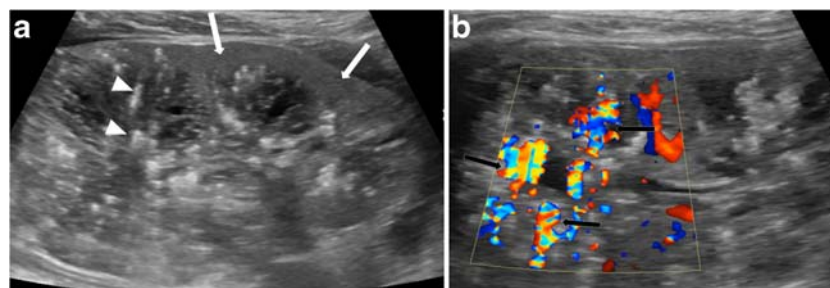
Boy of 6 years old with *HNF1B* mutation B-mode convex (a) and linear (b and c) probes; color Doppler (b) Enlarged kidney, abnormal corticomedullary differentiation with areas of cortical sparing (white
